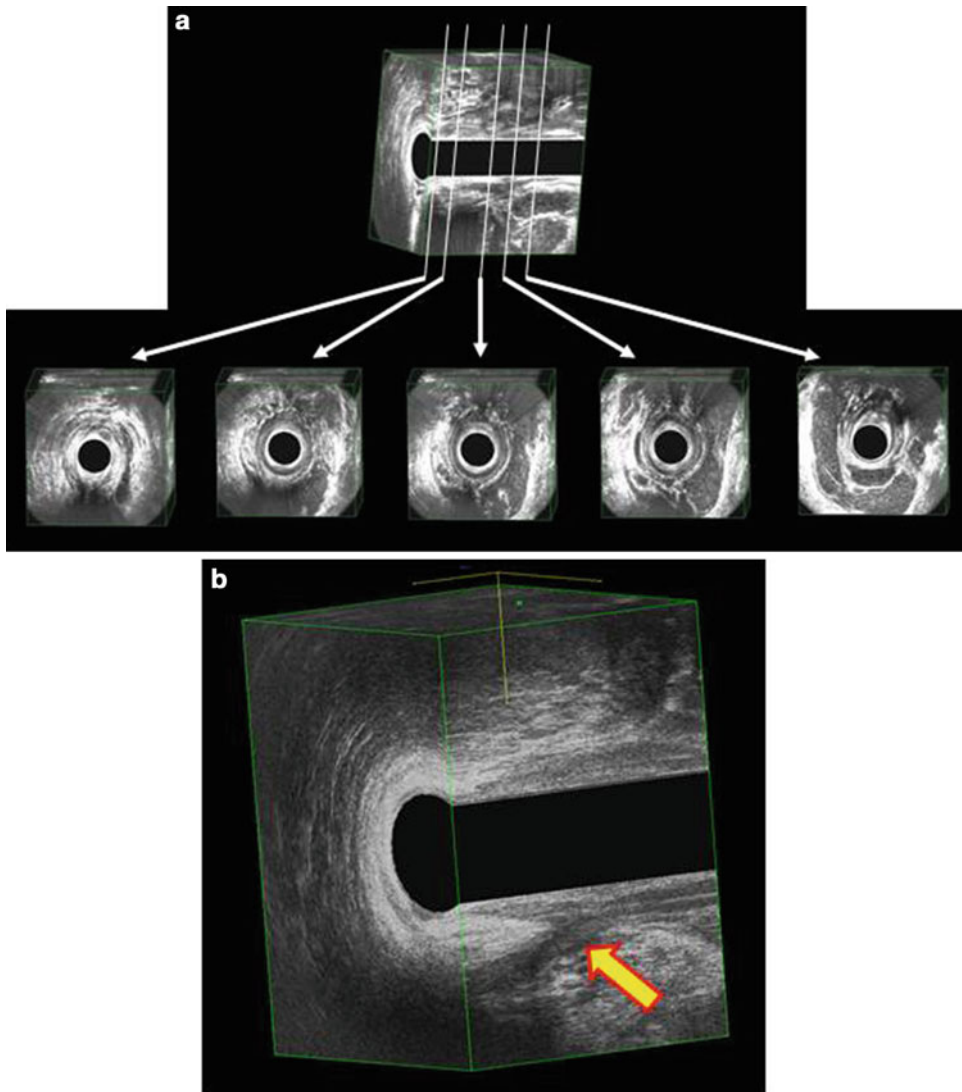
3D endoanal ultrasound: anal abscess with horseshoe extension (a), posterior transsphincteric anal fistula (b)
